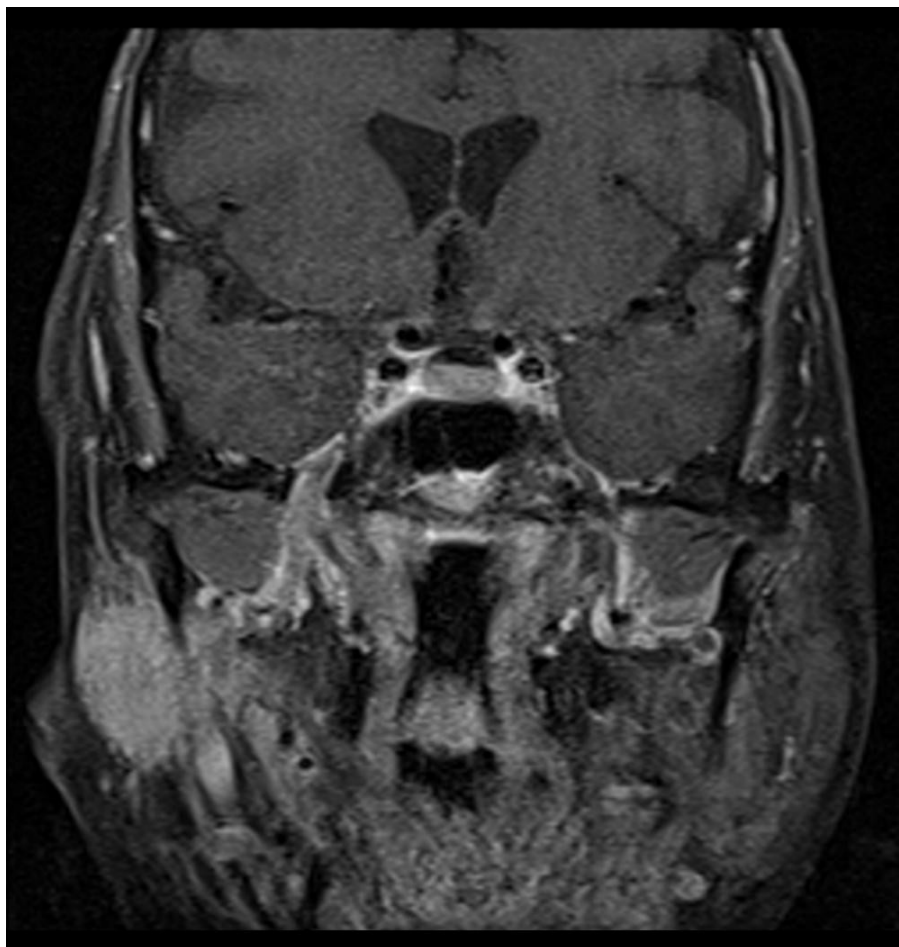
MRI example of perineural tumor spread along the facial nerve. Jto410, CC BY-SA 3.0, via Wikimedia Commons. Named-nerve disease should be followed toward the appropriate skull-base corridor rather than treated as a focal gland-bed finding.
